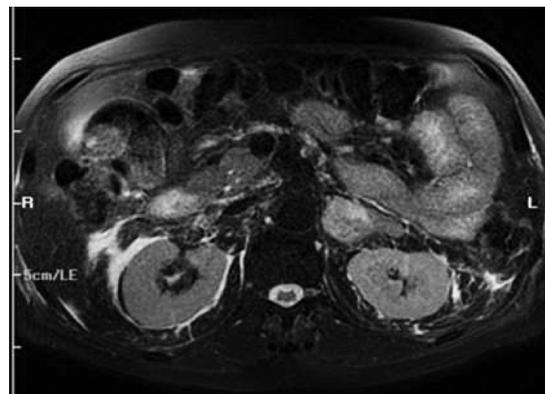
T2-weighted MRI shows high-signal pheochromocytoma in the left adrenal gland.
